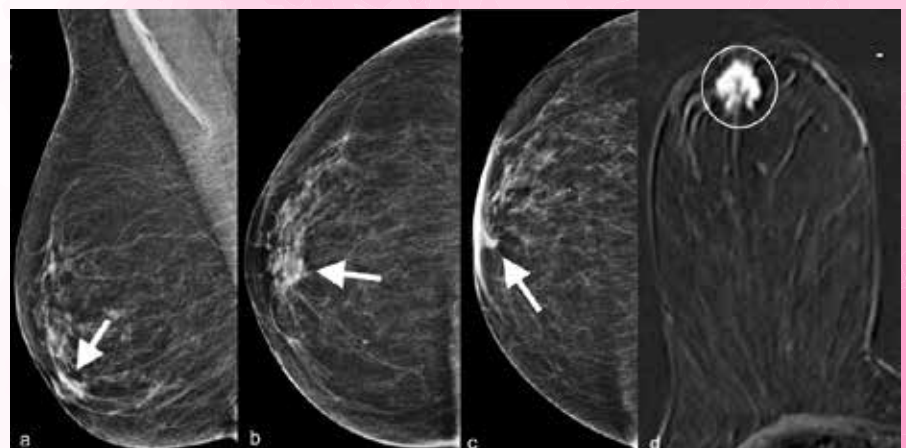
a. MLO and b. CC views of right breast do not depict retroareolar cancer (arrows). c. CC view with nipple in profile showing a retroareolar cancer (arrow). d. Corresponding post-IV-contrast T1-weighted subtraction MR image showing the retroareolar invasive ductal cancer (circle).
